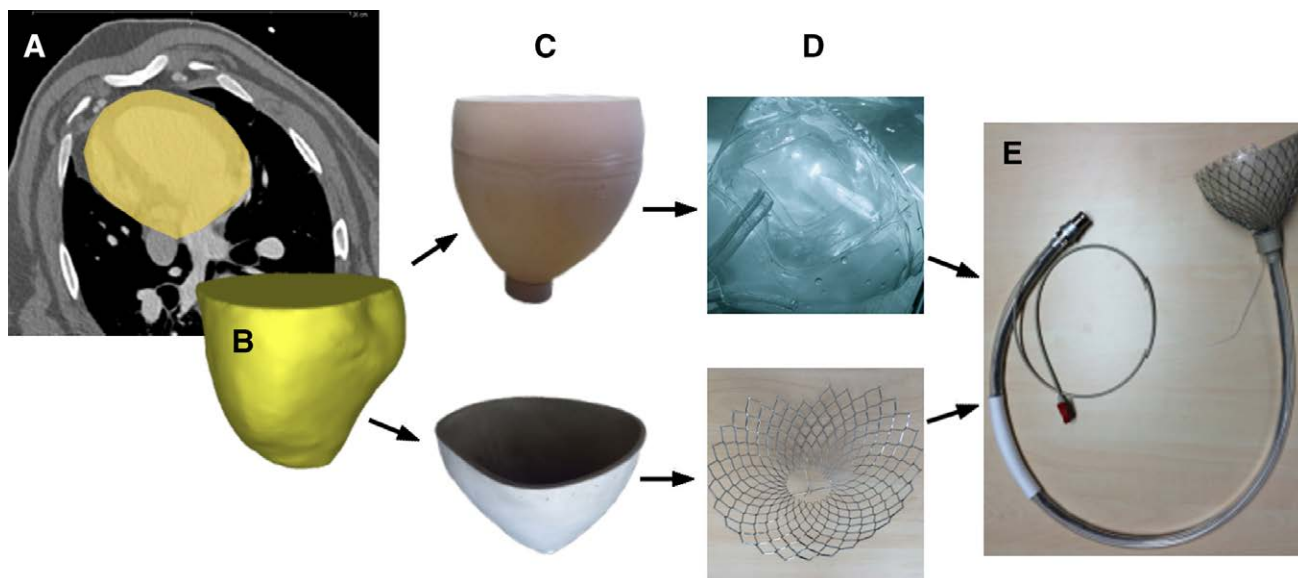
Patient-specific device manufacture: after segmentation of computer tomography (CT) data (A), three-dimensional (3D) surface rendering technique is used to create virtual 3D geometries (B). This is followed by the production of patient-specific implant forms (C), which serve as molds for the implant's components (D). These are assembled and connected to the pneumatic tubes (E). [full color online](#)
